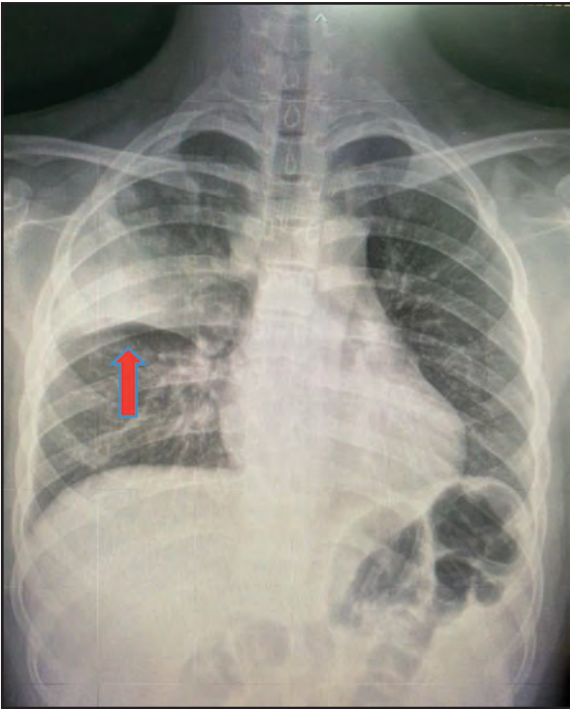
Chest radiography showing an ill-defined area of increased density in the right upper lobe without volume loss
